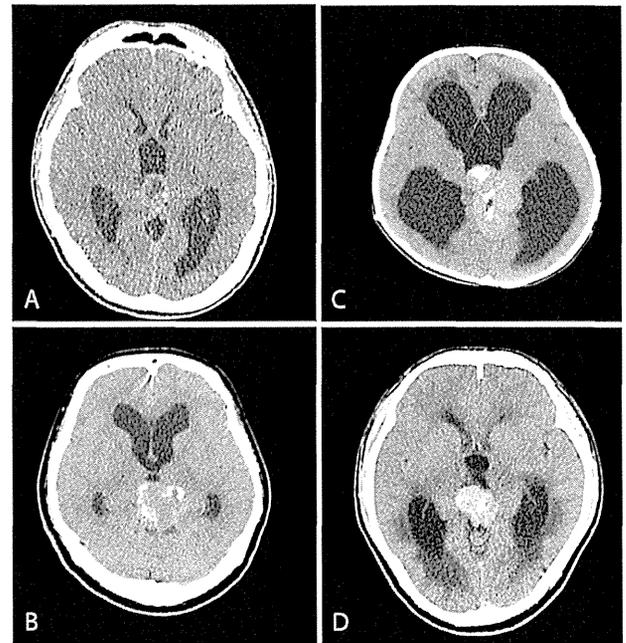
CT images of pathologically proven a pineocytoma, b PPTID, c pineoblastoma, and d germinoma. They have mean CT values of 36.1, 32.8, 45.0, and 49.5 HU, respectively. Cases a, b, and c show “exploded” calcification, whereas case d shows “engulfed” calcification. *HU* Hounsfield unit, *PPTID* pineal parenchymal tumor of intermediate differentiation
